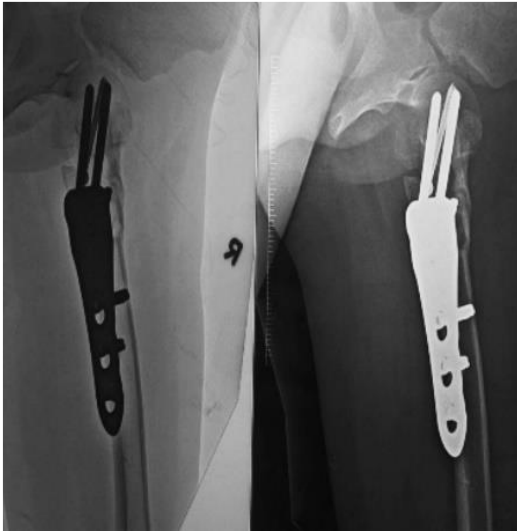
Immediate post-operative X-ray (A.P. view)
